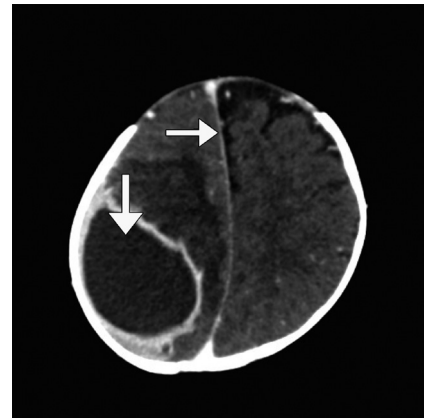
Computed tomography (CT) scan of the brain showed a large, 6x4x3.7 cm hypodense area likely extra axial location in the right high posterior parietal region with enhancing wall suggestive of empyema/abscess with mass effect and displacement and compression of ipsilateral right frontal horn and mild dilatation of left frontal and right temporal horn of lateral ventricle and midline shift to the left by 8-9mm. There is reduced density of a large area of the underlying right posterior frontal and parietal brain regions, likely edema.
